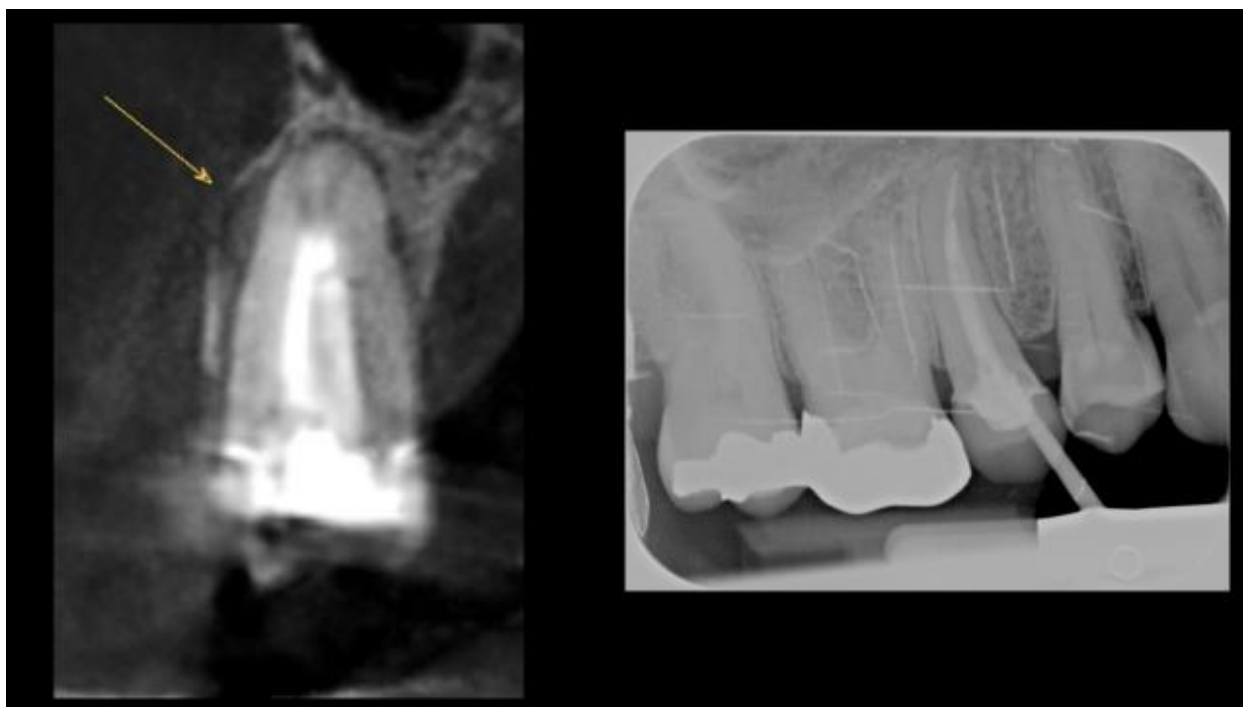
Indirect root fracture #4 CBCT (left) not visible on PA (right)
